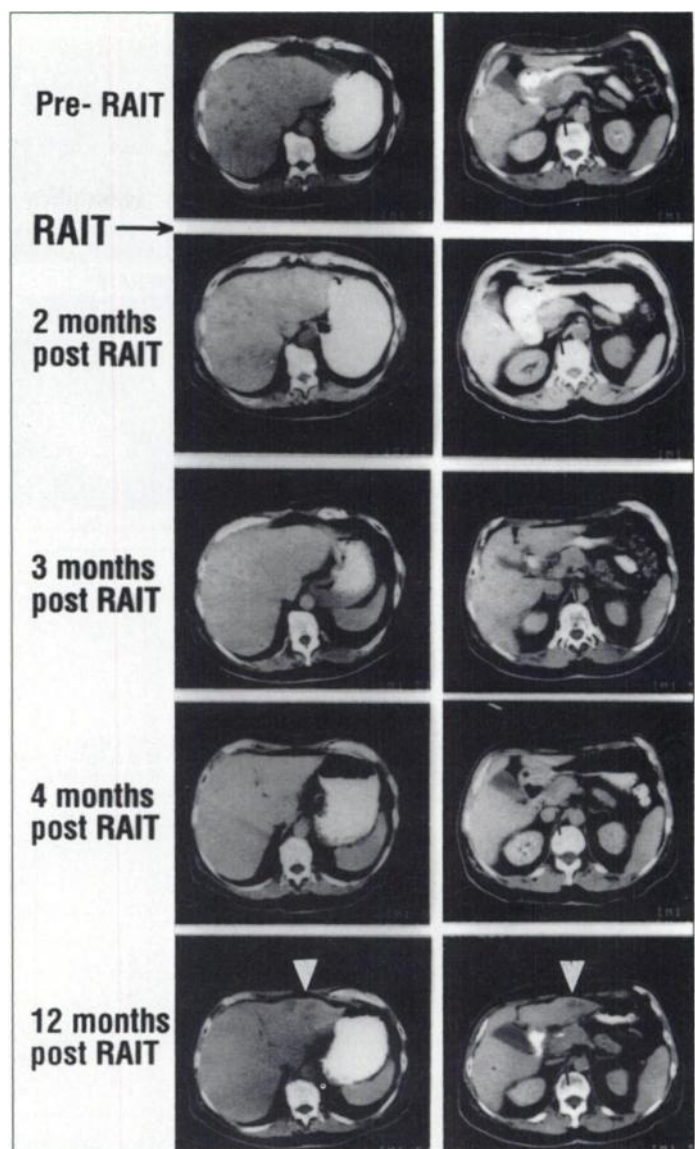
Abdominal CT of Patient 589, a 66-yr-old man with a pancreatic cancer metastatic to the liver. The baseline CT shows multiple small liver metastases and the primary in the pancreatic head (arrow). RAIT with 146.2 mCi of ¹³¹I-labeled NP-4 IgG led to a complete disappearance of all liver lesions in the 4-mo follow-up, whereas the pancreatic primary (arrows) was unchanged in size (i.e., a partial remission). This was maintained until 12 mo post-RAIT, when new lesions in the left hepatic lobe (white arrowheads) appeared.
